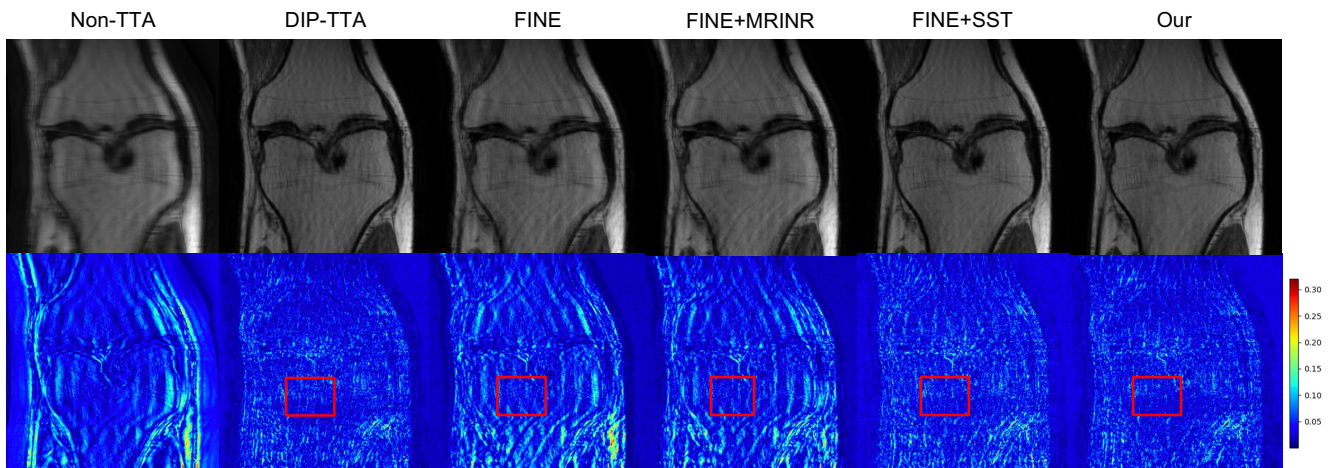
Comparison of different frameworks in Varnet under acceleration shift (2X to 4X) using the FINE method. The first row shows reconstructed MRI images, while the second row presents residual maps between reconstructions and full-sampled MRI.
